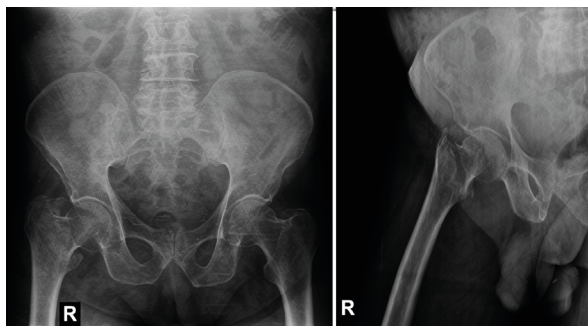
AP X-ray of pelvis and lateral X-ray of right hip showing right pertrochanteric fracture
